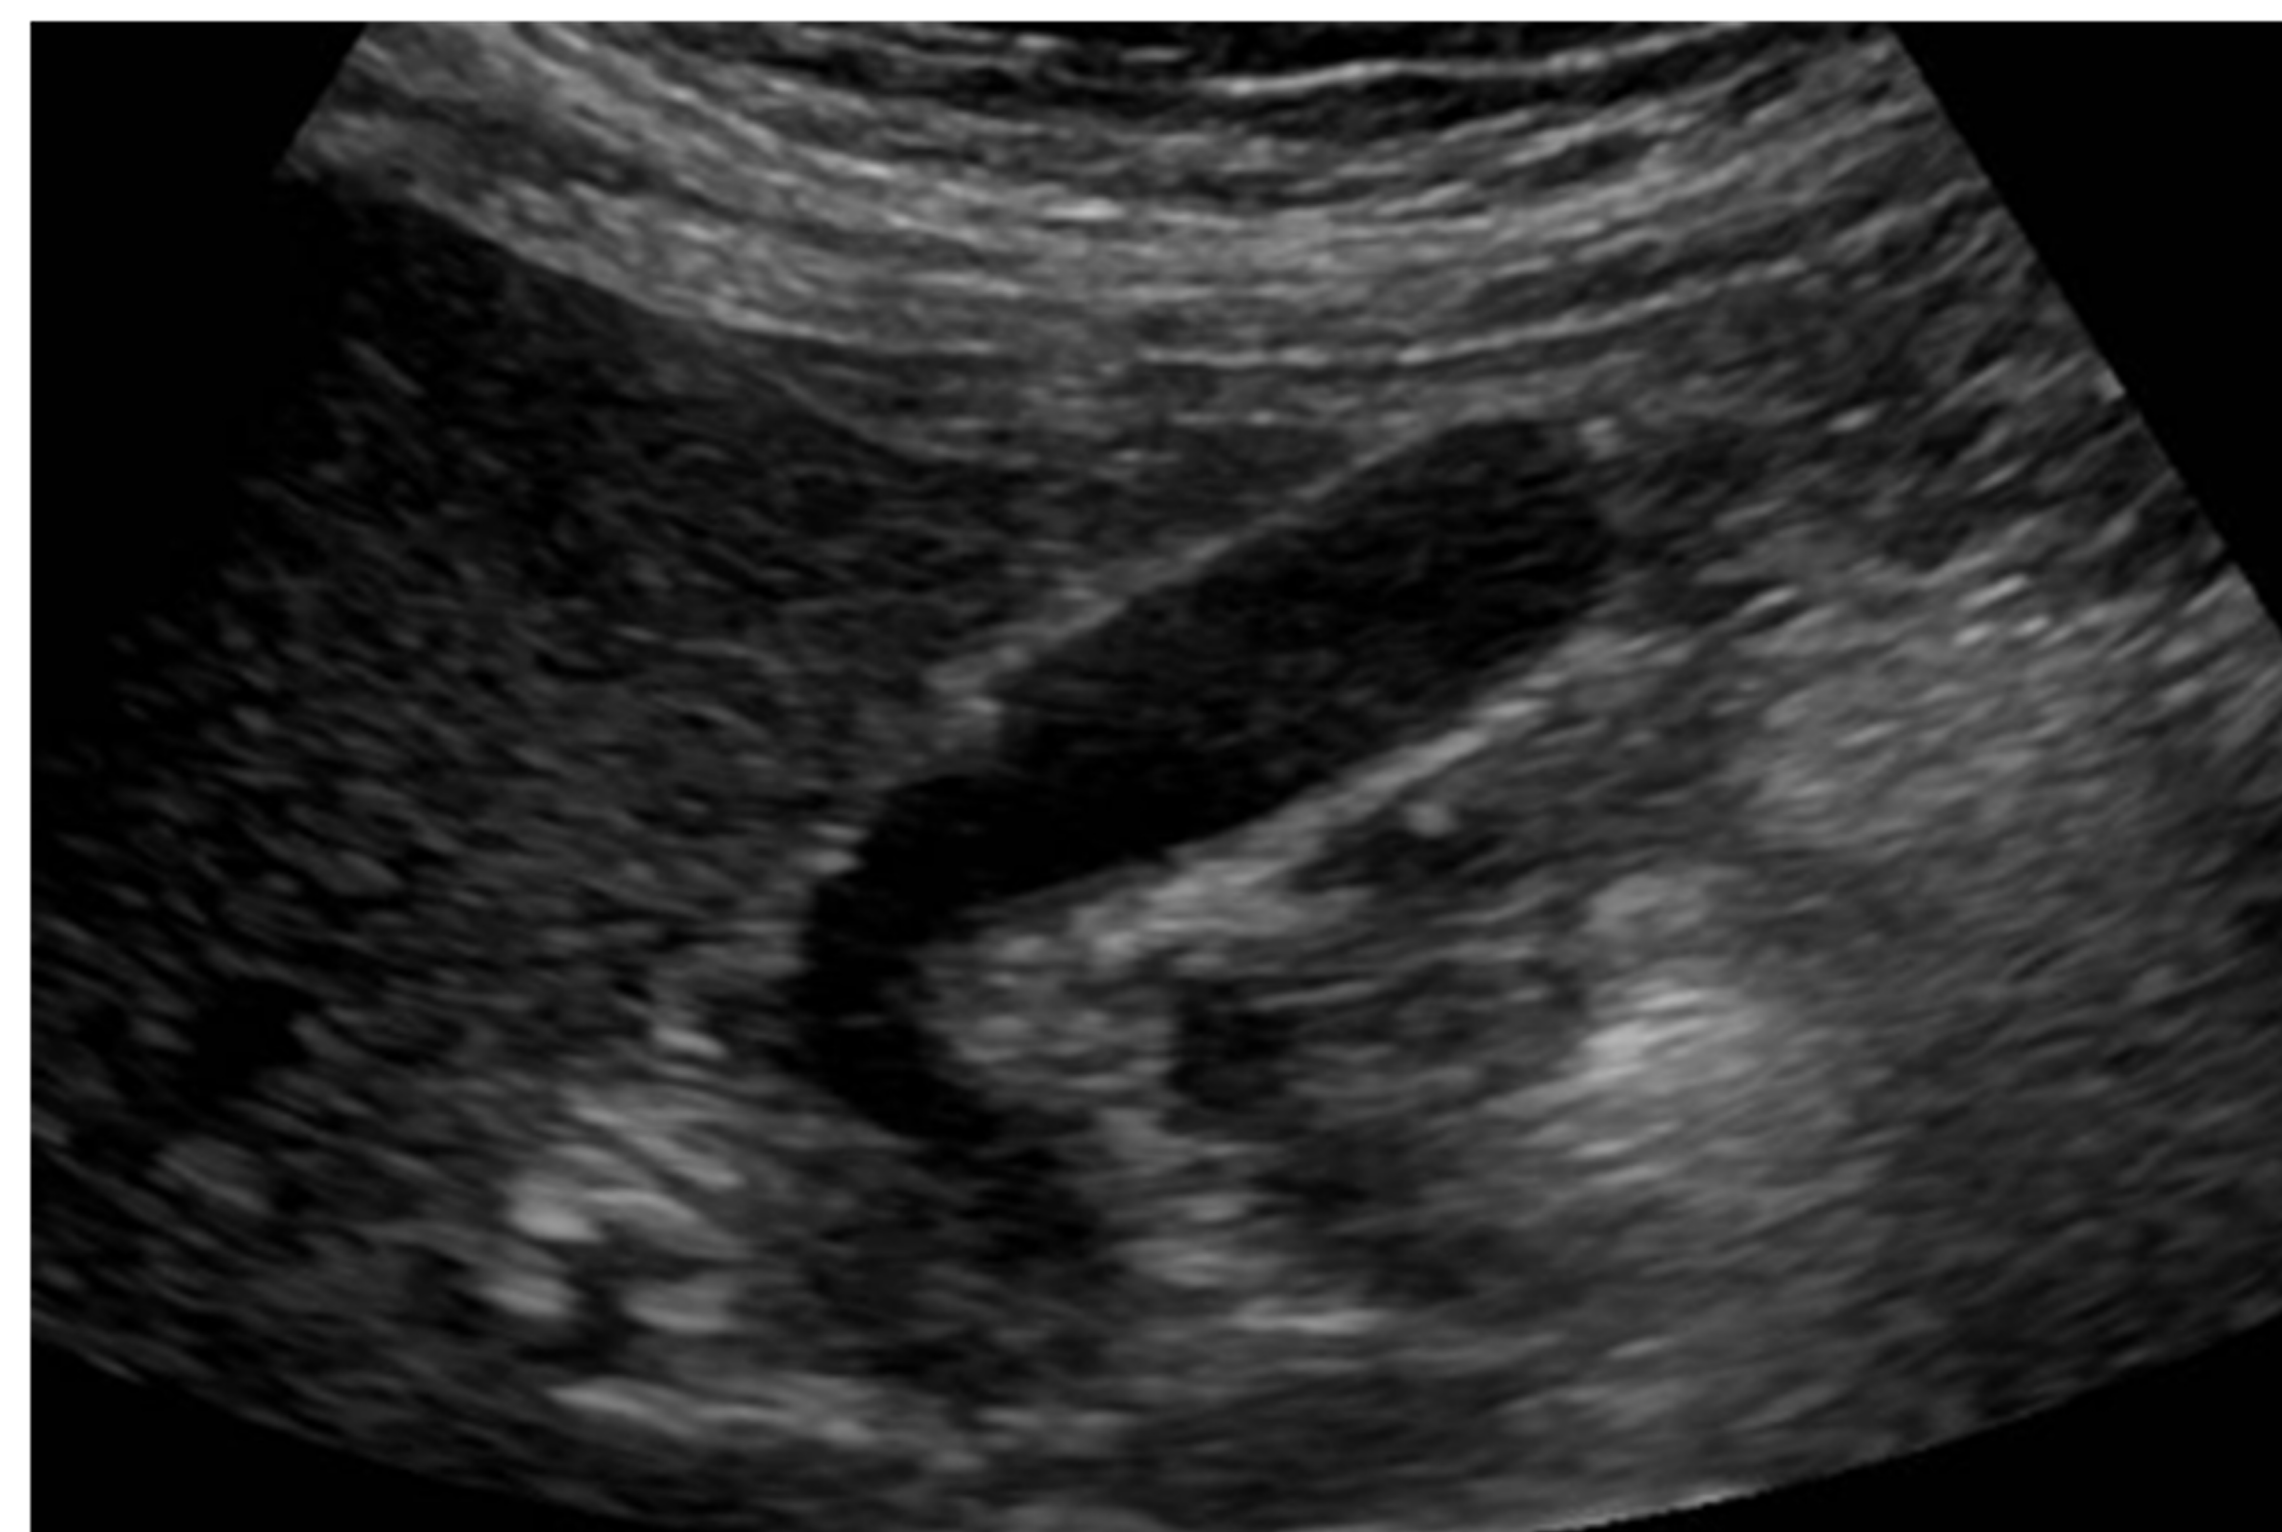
Transverse Right Upper Quadrant Ultrasound in Left Lateral Decubitus positioning indicating nondistended gallbladder, no pericholecystic fluid, nor any gallstones. Sonographic Murphy's sign was negative.
